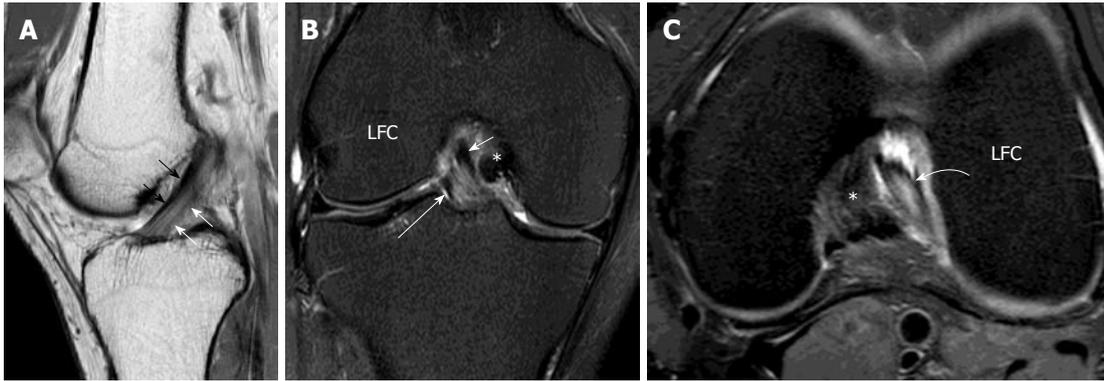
Normal anterior cruciate ligament. Volunteer, 24-year-old man with no history of injury and clinical instability. Sagittal intermediate-weighted magnetic resonance (MR) of the knee. A: Demonstrates a normal anterior cruciate ligament (ACL) which is characterized by a taut, continuous, low signal intensity fibres extending from the tibial plateau anteriorly to the medial aspect of the lateral femoral condyle. The more anterior portion of ACL is the anteromedial (AM) bundle (black arrows) while the more posterior portion is posterolateral (PL) bundle (white arrows). They cannot be well delineated from each other on this sagittal image. The PL bundle shows higher signal intensity than AM bundle. Coronal T2-weighted fat suppression MR knee image; B: The mid and distal ACL in the intercondylar fossa. The fibres are running superiorly and laterally within the intercondylar fossa from tibial attachment to the lateral femoral condyle (LFC). The more medial portion is the AM bundle (white short arrow) while the lateral portion is the PL bundle (white long arrow). Axial intermediate-weighted fat suppression MR image; C: Normal mid substance of ACL (curved white arrow). The ACL is elliptical in appearance because it is running obliquely to the scan plane. The two bundles cannot be differentiated from each other. *: Posterior cruciate ligament.
